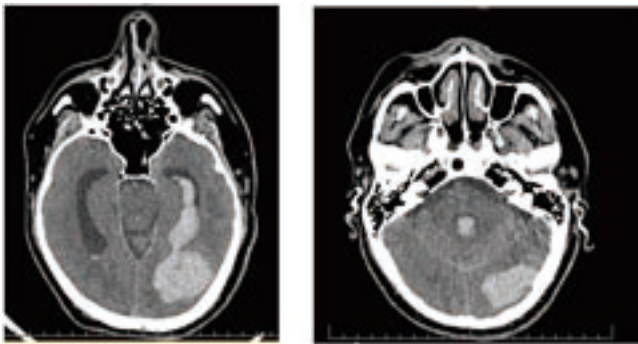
Brain CT showing intracerebral hemorrhage after thrombolysis in a patient with myocardial infarction.
